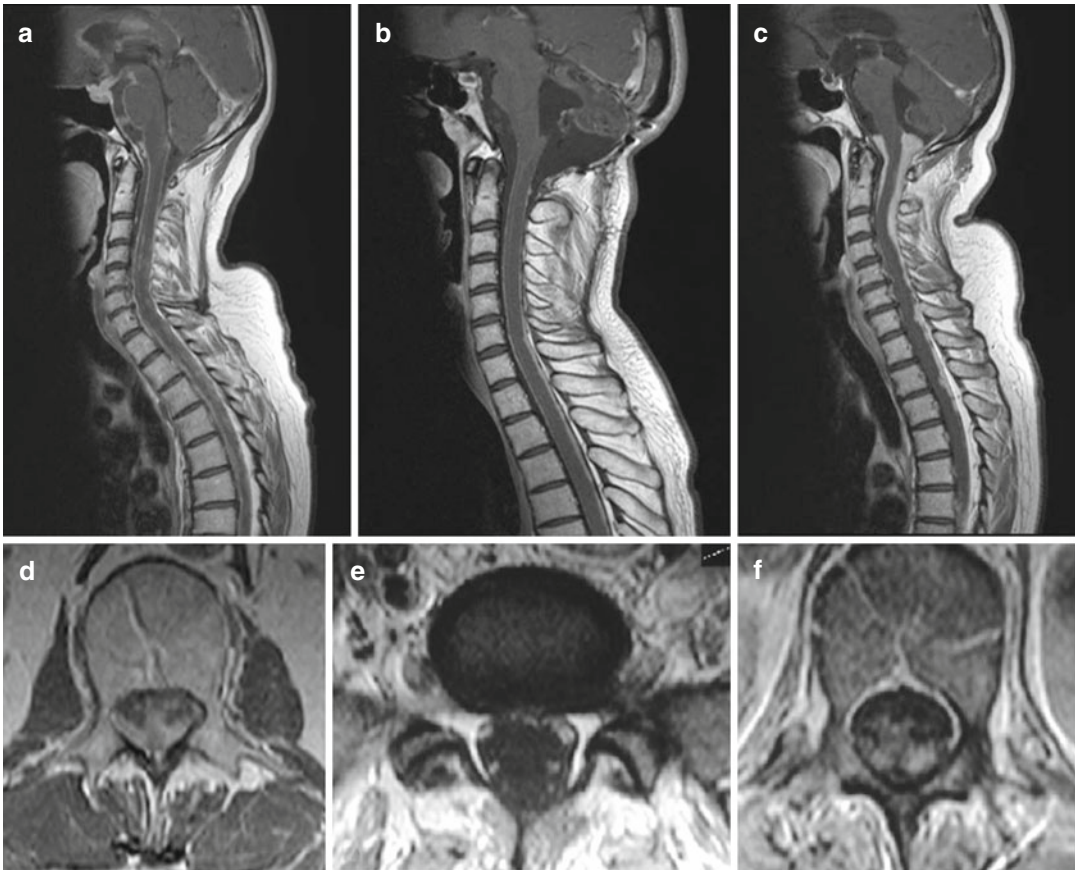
Leptomeningeal metastases. Sagittal T1-weighted images with contrast medium, (a–c), show spread of high-grade gliomas in three different cases. Note in (c) the complete filling of CSF spaces by pathologic enhancement; CSF spinal dissemination of HGG
